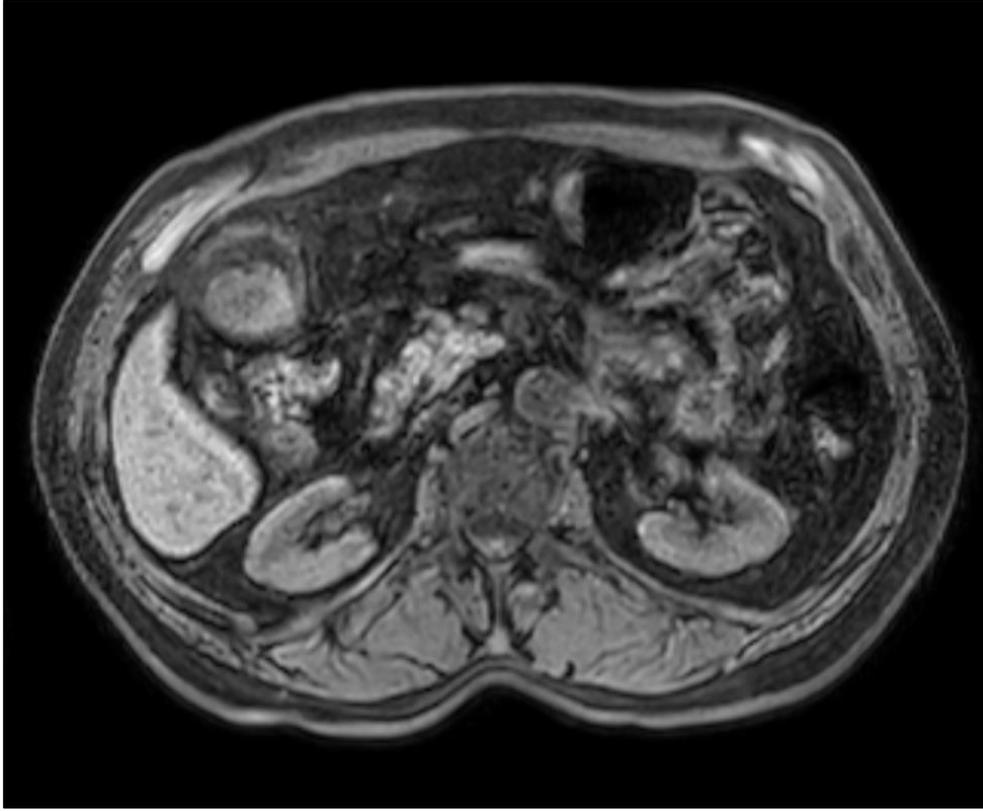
Hyperintense mass-like lesion in the gallbladder on T1-weighted axial MR image.
